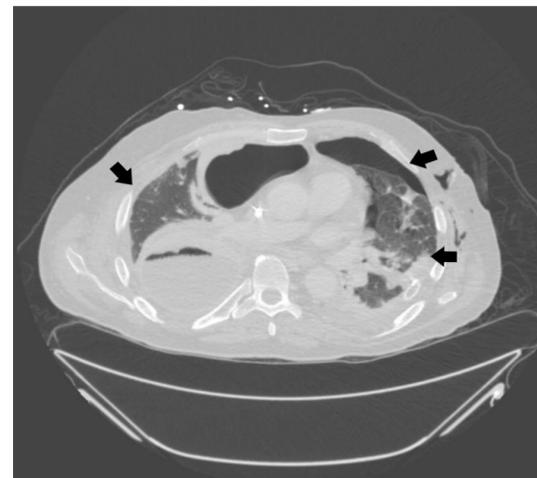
A: Axial Chest CT with Contrast shows moderate size left pneumothorax, left pleural effusion, loculated pneumothorax
